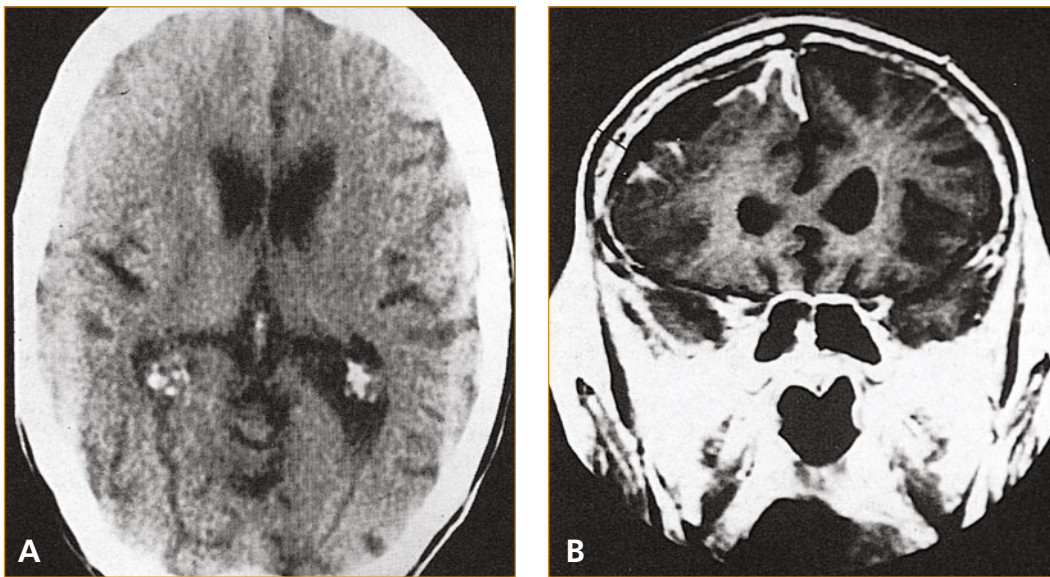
CT scan with contrast and MRI scan of subdural empyema done as part of a diagnostic work-up. A, CT scan reveals effaced sulci over the right hemisphere, with only minimal mass effect. B, However, MRI scanning with contrast reveals the large subdural empyema with mass effect.
